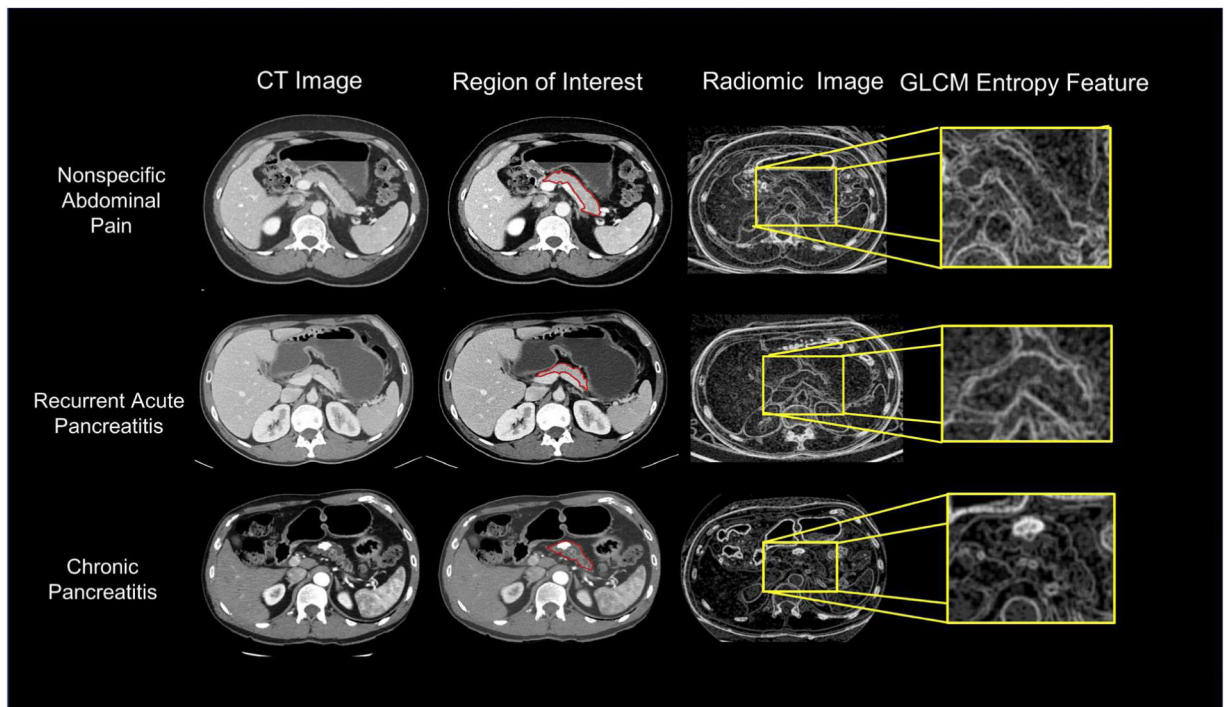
CT and radiomic sample images based on diagnosis.
